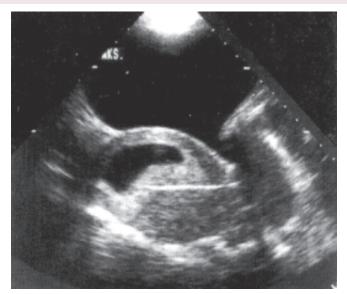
Transcervical ultrasound-guided chorionic villus sampling
